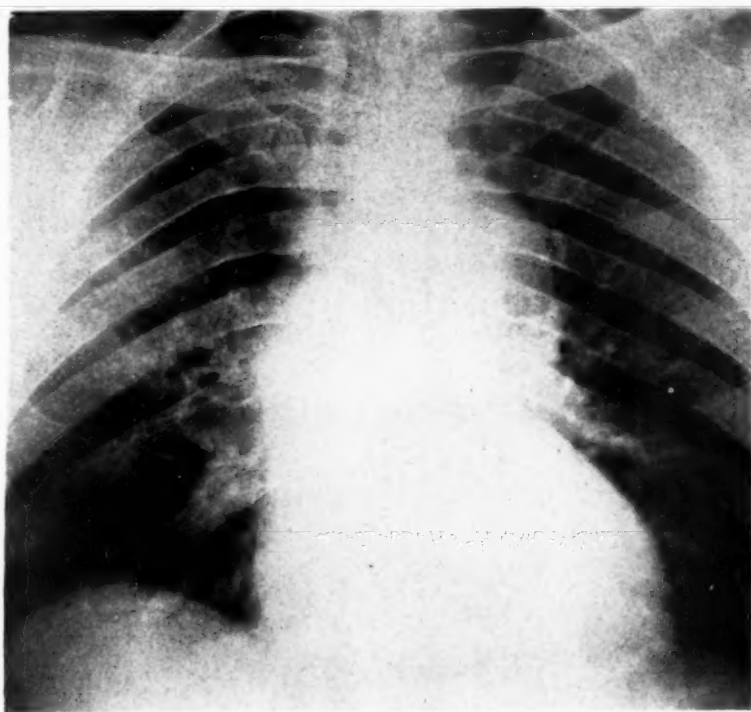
X-ray photograph of chest showing aneurysmal dilatation of aorta with trachea displaced to right.
